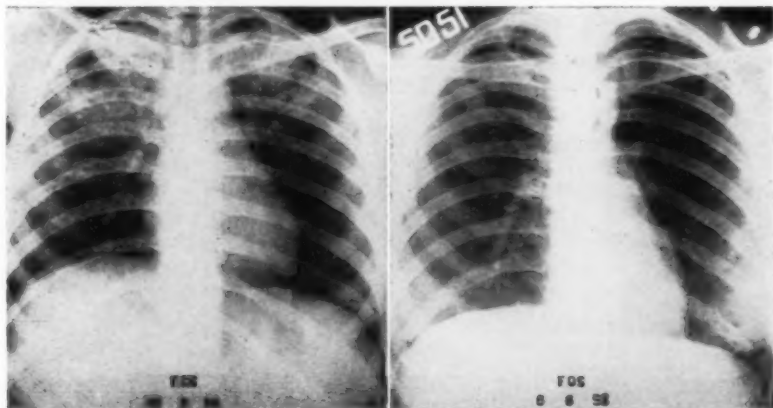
(Case 2): F. C. S., Chest roentgenogram, February 13, 1958 showing diffuse miliary process.
